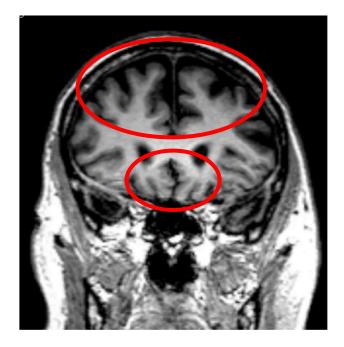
Coronal MRI scan displaying the typical frontal lobe atrophy in the behavioural variant of frontotemporal dementia (bvFTD).
